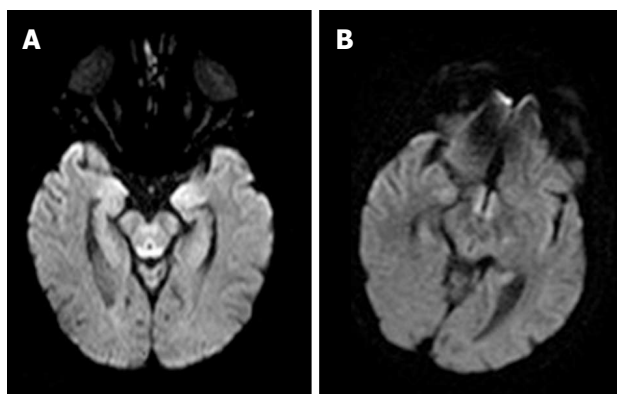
Axial diffusion weighted image magnetic resonance images in a patient with alcoholic Wernicke's encephalopathy in the acute phase. A: Diffusion weighted image shows restricted diffusion in the periaqueductal grey matter; B: Diffusion weighted image shows restricted diffusion around the mammillary bodies.
